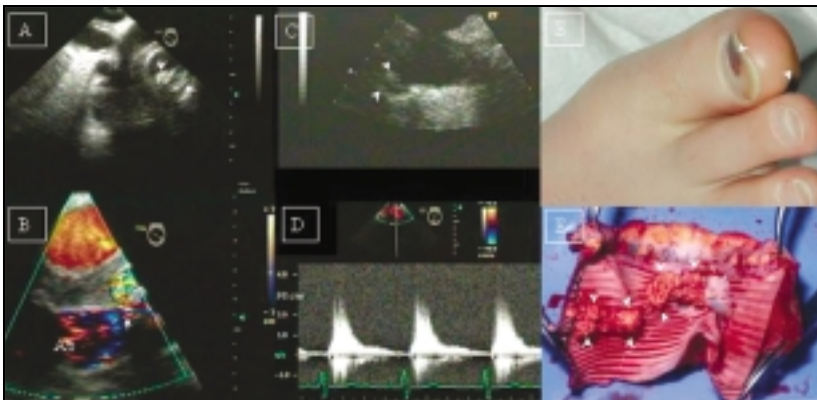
Photographs of the transesophageal and transthoracic echocardiograms (A–D) obtained in Patient 3. Transesophageal cross-sectional views through the mid-ascending aortic graft showing irregular echo-dense structures within the aortic graft (A, white arrowheads) and turbulent blood flow on color Doppler image within ascending aorta entering a shelf within the aortic graft (B, white arrow). Mobile echo densities in the distal ascending aorta are shown by transthoracic echocardiography on suprasternal view (C, white arrowheads). Continuous-wave Doppler revealed a gradient of 36 mm Hg across the distal ascending aorta (D). Photograph of right foot obtained at the time of presentation shows hemorrhagic lesions on the big toe (E, white arrows). Photograph of transected aortic graft shows multiple vegetations within the graft (F, white arrows).
